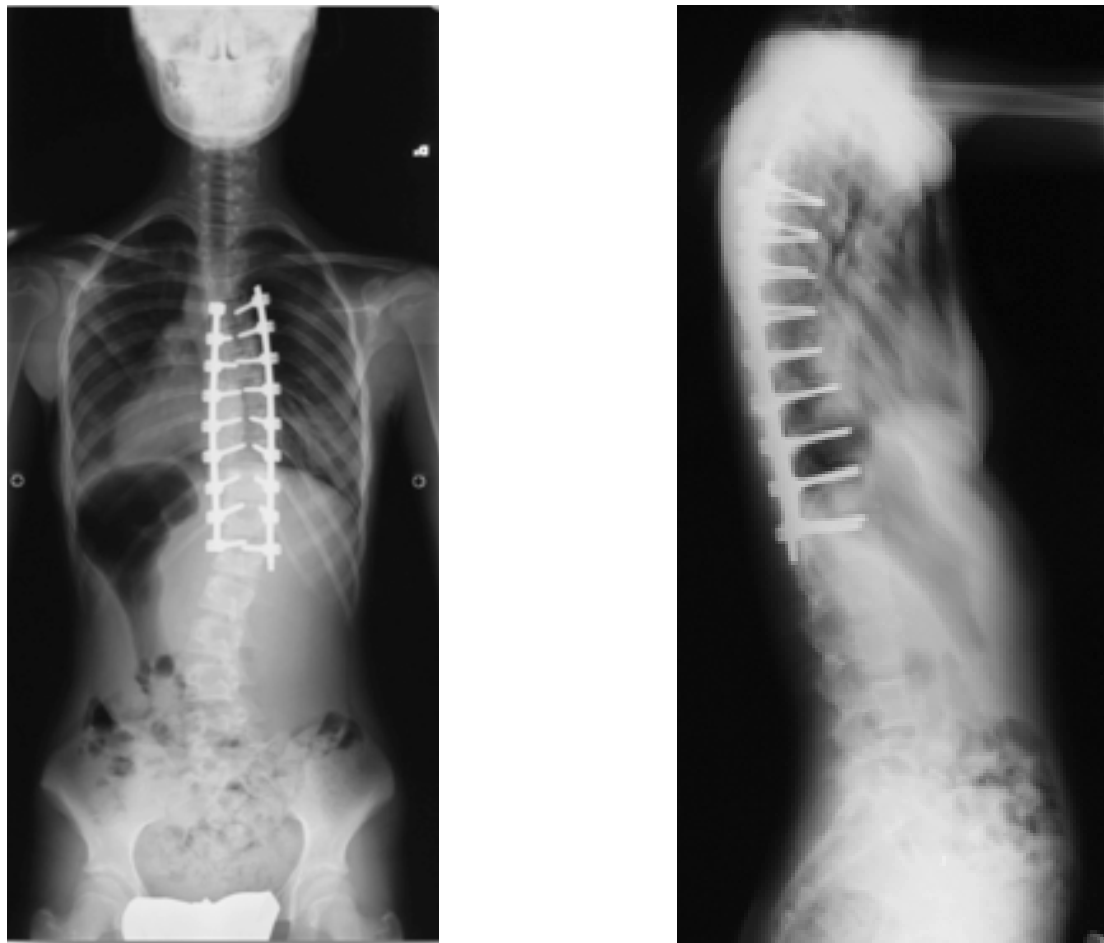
Postoperative radiograph on frontal (a) and sagittal (b) plane.
